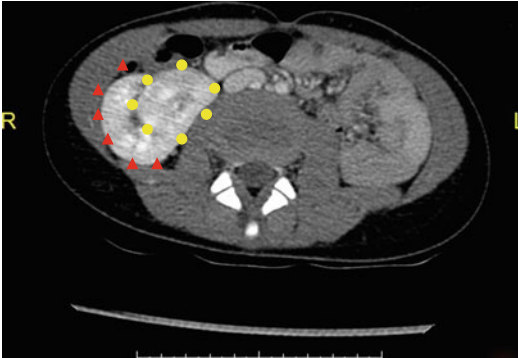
Axial CT image of crossed fused renal ectopia with both kidneys (*red triangles and yellow circles*) on the right side
